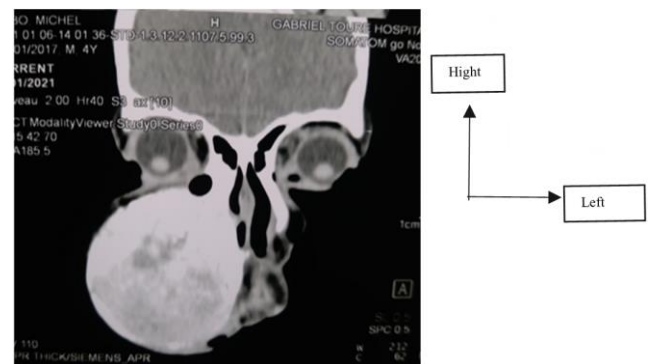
Coronal section CT image showing the hyperdense mass in the maxillary sinus with mass effect on the ipsilateral nasal cavity.
